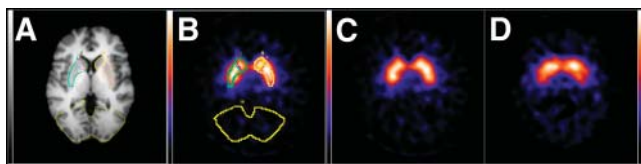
^{123}I -FP-CIT SPECT analysis of striatal dopamine transporter availability in adults with attention deficit/hyperactivity disorder (ADHD) found significantly reduced binding ratios in the whole striatum, in all striatal subregions, and in the thalamus in individuals with ADHD (D) compared with normal controls (C). (A) and (B) represent MR-based region-of-interest analyses of imaging activity.
